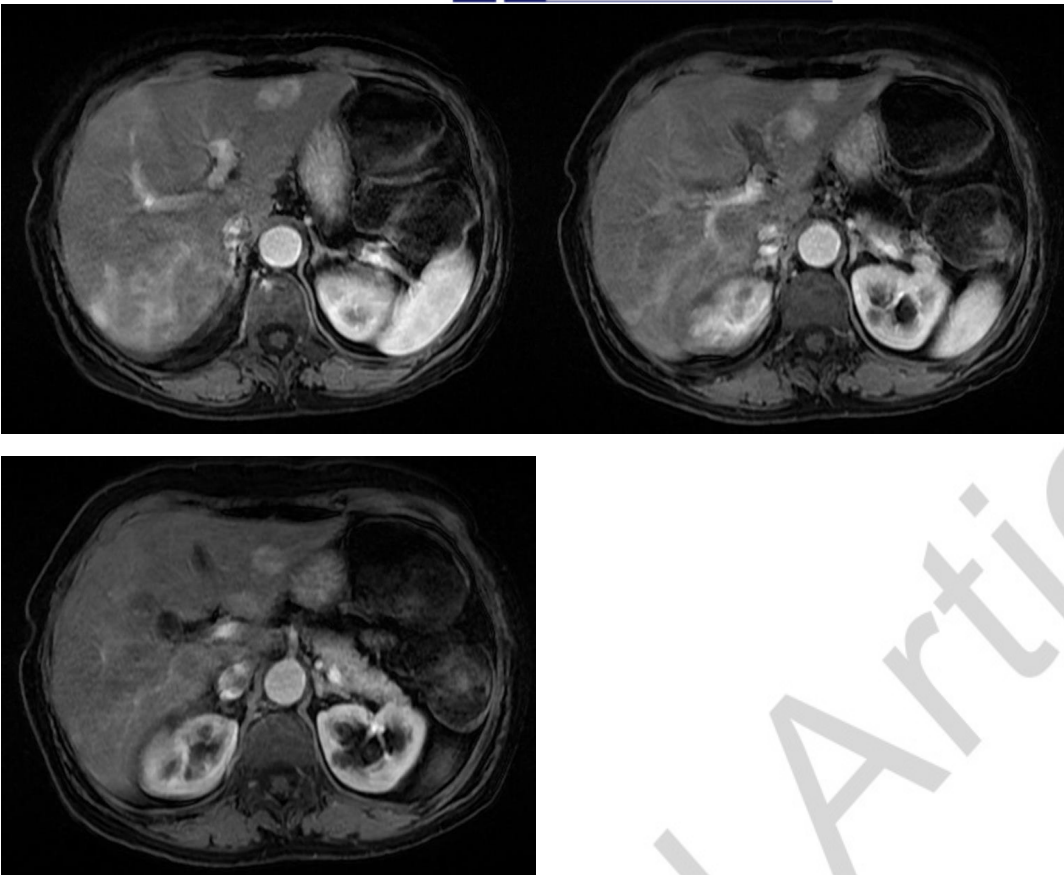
A-C. Liver magnetic resonance image at disease diagnosis showing synchronous, multiple and bilobar colorectal cancer liver metastases (15 metastases).
